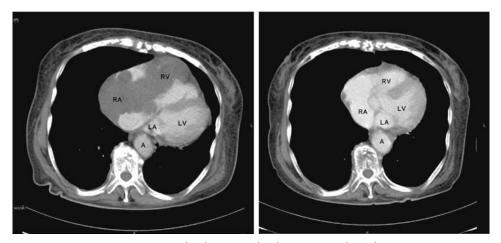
Computed tomography (CT) before (left) and after (right) chemotherapy. The giant tumor in the right atrium infiltrated into the right ventricle (left). RA, right atrium ; RV, right ventricle ; LA, left atrium ; LV, left ventricle ; A, aorta.
